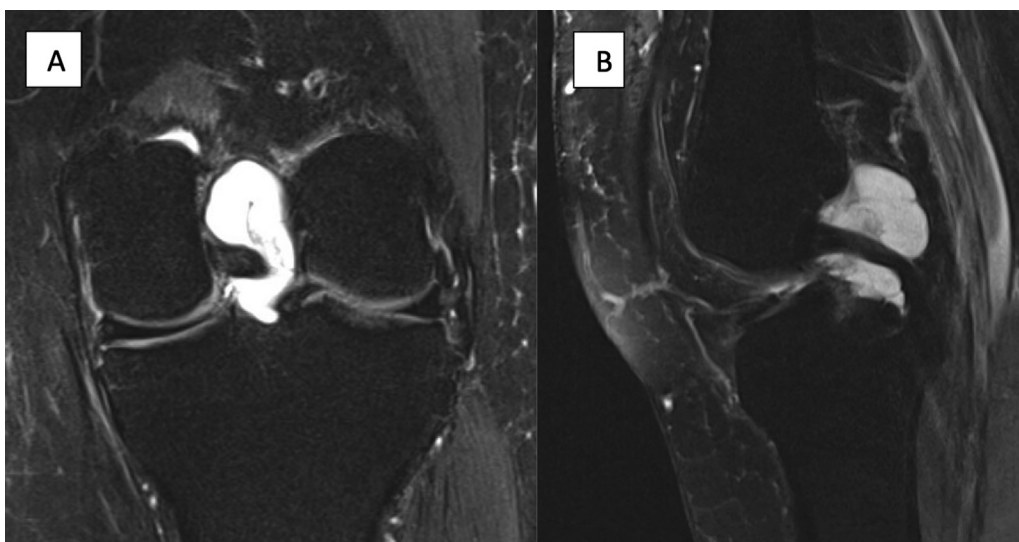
Parameniscal cyst extending into notch. A 48-year-old woman presented with a 4-month history of knee pain. She described a pain deep in the knee with associated limited range of motion. She noted one episode of mechanical locking. Pain was worse with stairs, squatting, and running. She denied previous knee surgery and had a remote history of patellar dislocation. On examination, she had a mild effusion, range of motion from 5 to 90 degrees, positive McMurray's test, and medial joint line tenderness. MRI revealed tear of the posterior horn of the medial meniscus and associated parameniscal cyst extending into the notch. (A) Coronal STIR image showing cyst occupying notch. (B) Sagittal STIR image with cyst extending into posterior aspect of the knee.
